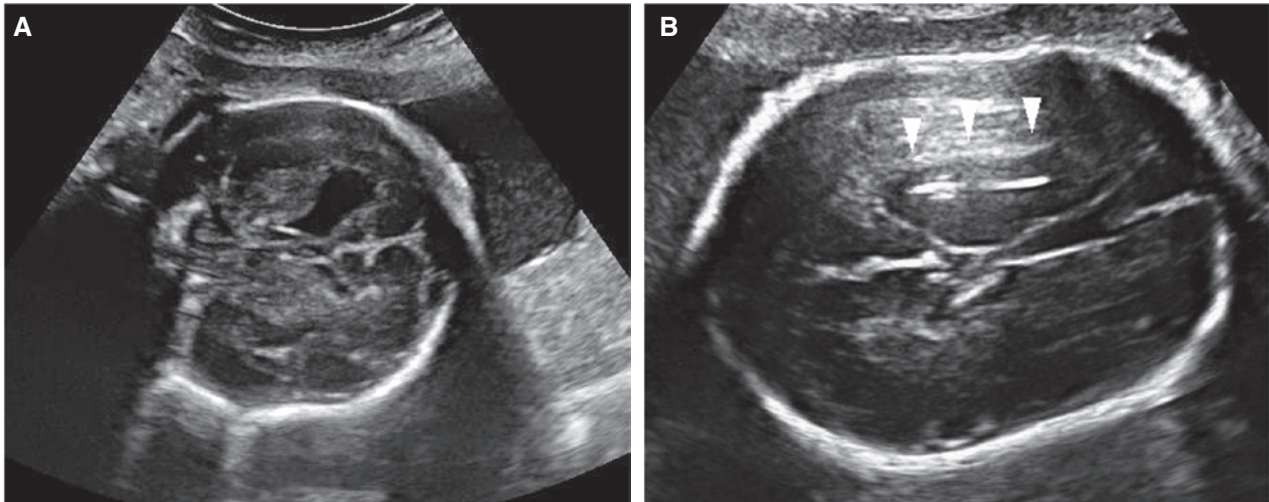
Fetal neurosonography at 28 weeks of gestation. (A) Coronal section of fetal head. Comparing to the left ventricle, see enlarged right lateral ventricle expanding into the hemisphere. (B) Unilateral focal enlargement of the right lateral ventricle on transversal section (white arrowheads).
